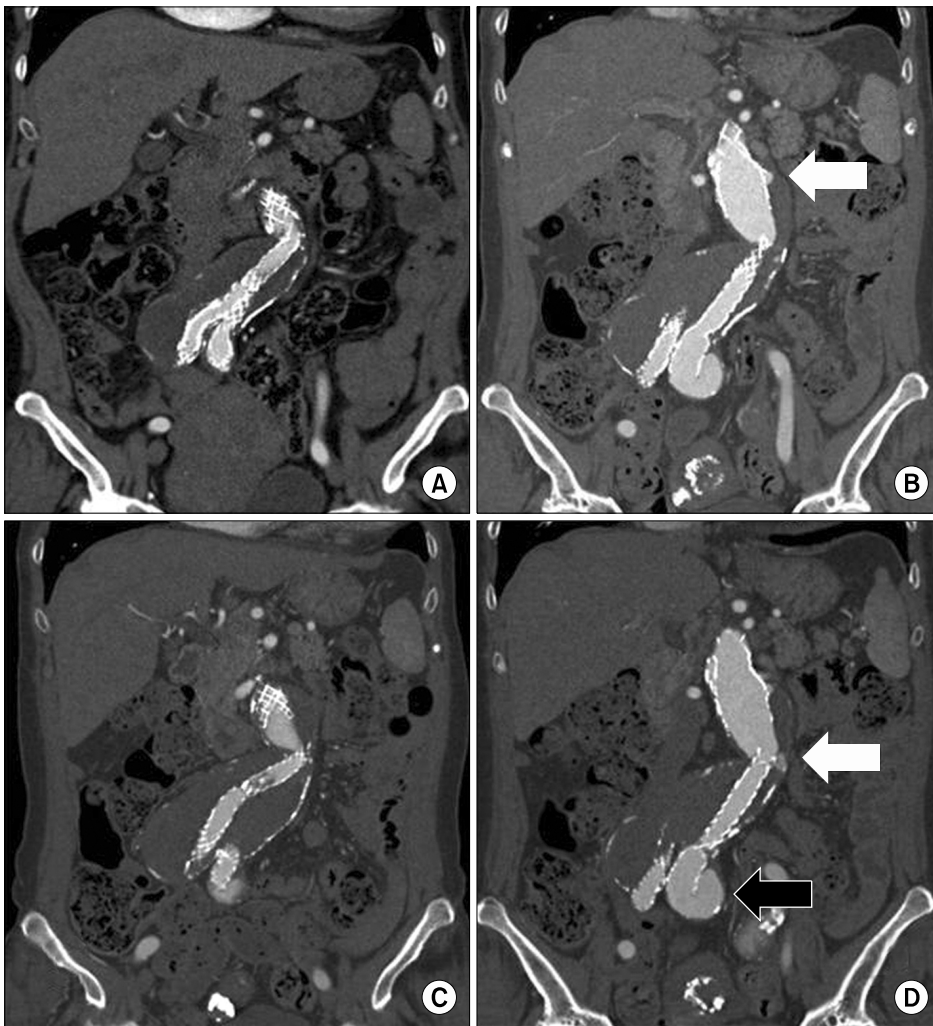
CTA after endovascular aortic repair. (A) The CTA images taken immediately postoperatively show the kinked endograft making contact with the aortic wall. (B-D) A CTA image taken 6 years postoperatively shows that the endograft kinking had worsened (C), and type Ia (white arrow in B), type 3 (white arrow in D), and type 1b (black arrow in D) endoleaks were observed. CTA, computed tomographic angiography.
